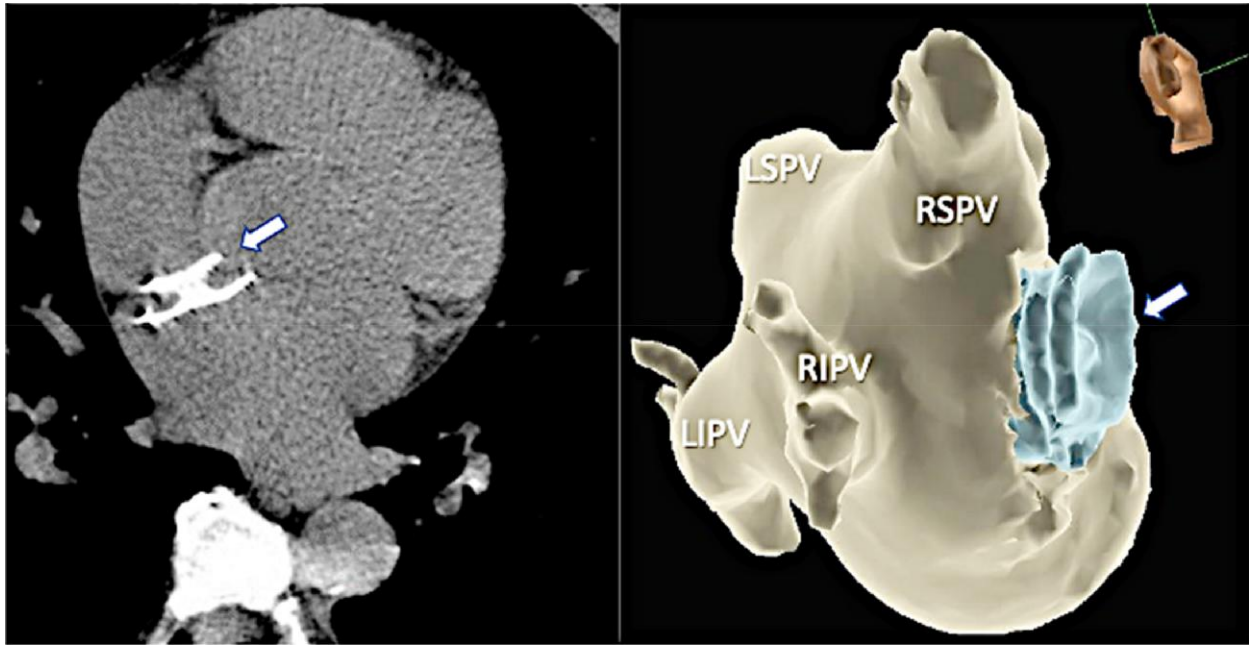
Reconstruction images of computed tomographic angiography of the left atrium showing the location of the Amplatzer septal occluder device (white arrow). LSPV, left superior pulmonary vein; LIPV, left inferior pulmonary vein; RIPV, right inferior pulmonary vein; RSPV, right superior pulmonary vein.
